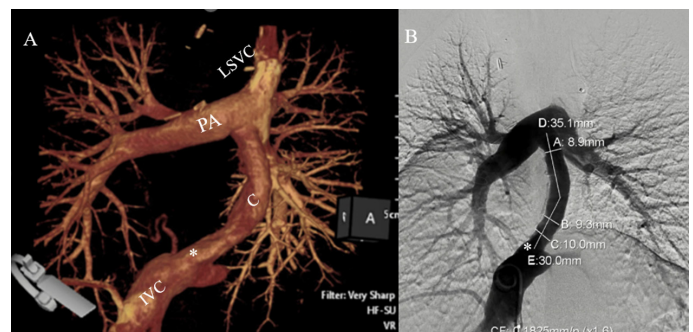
Preoperative computed tomography scan (A), and cardiac catheterization (B) showing diffuse calcifications in the extracardiac Fontan conduit and significant narrowing at the inferior vena caval/conduit anastomotic site (asterisk). Notice the significant reduction (almost 50%) in the actual conduit diameter from the original 16 mm as measured on cardiac catheterization which is attributed to most likely to an ongoing intimal proliferation IVC: Inferior vena cava, C: Conduit, LSVC: Left superior vena cava, PA: Pulmonary artery
